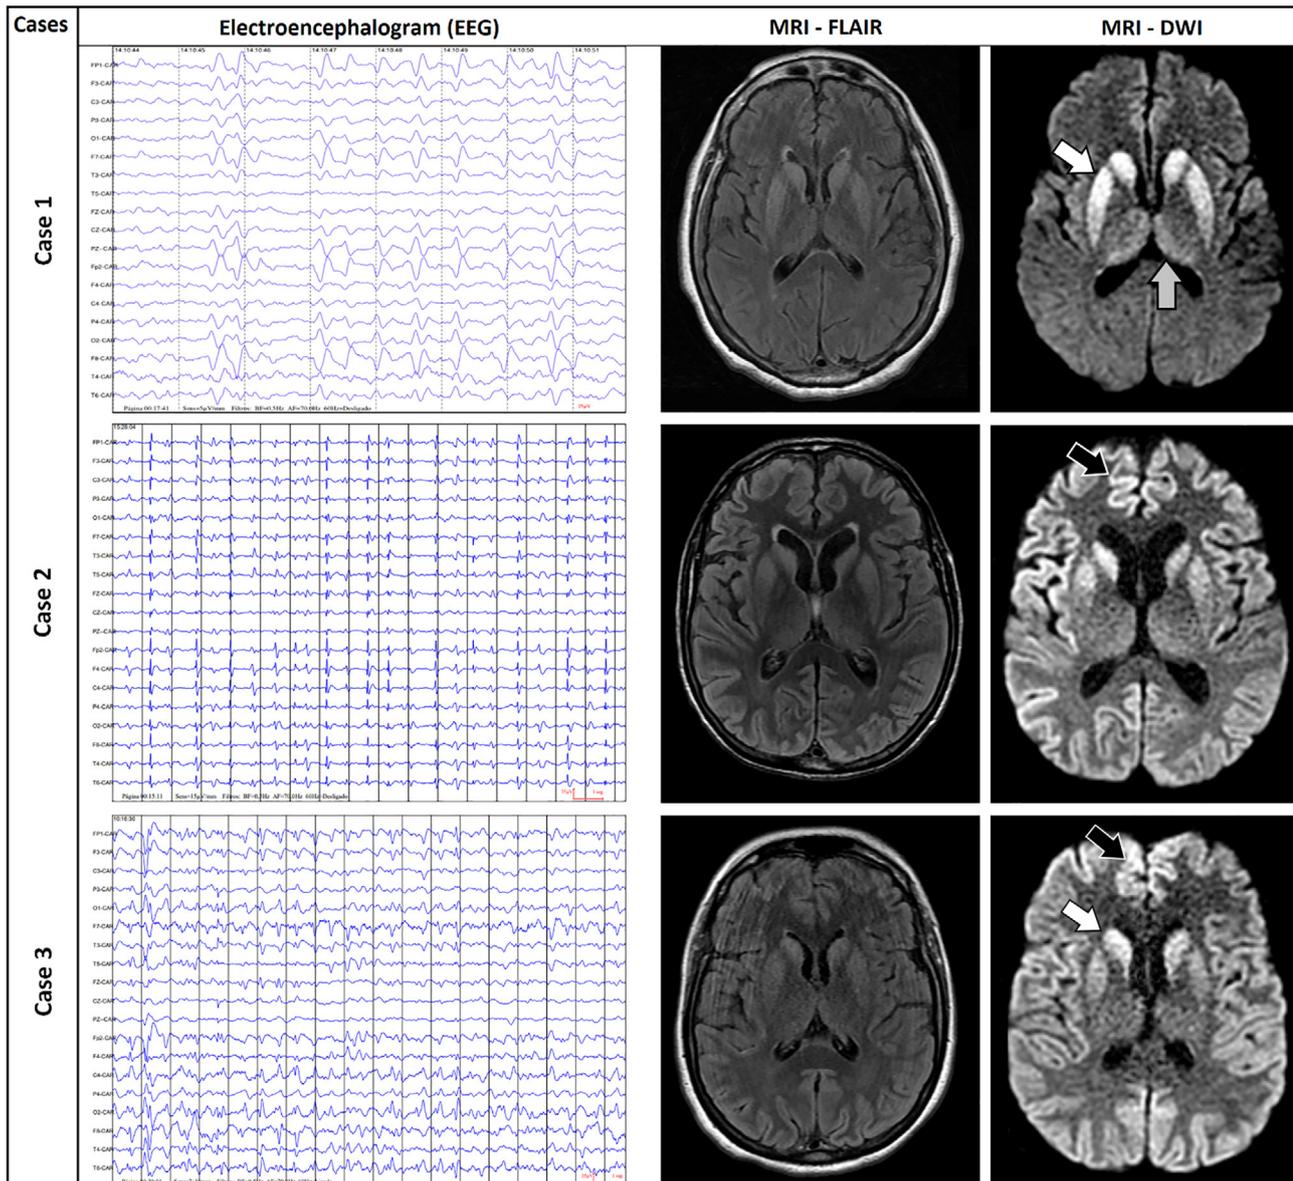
Axial diffusion-weighted and fluid-attenuated inversion recovery images showing bilateral involvement of the basal ganglia (Cases 1 and 3 – white arrows) and thalami (Case 1 – gray arrow). Axial diffusion-weighted shows more widespread signal hyperintensity in the cortical ribbon (Cases 2 and 3 – black arrows). Those findings are reported as usual Creutzfeldt-Jakob disease magnetic resonance imaging signs. Regarding the electroencephalograms, it is possible to note a diffuse repetitive triphasic wave discharges pattern with short periodicity in Case 1 and diffuse repetitive wave discharges pattern with short periodicity in Cases 2 and 3.
